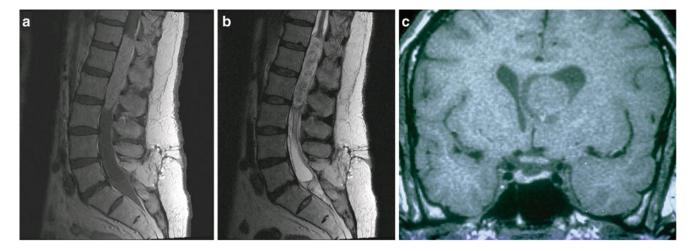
(A, B) Myxopapillary ependymoma. Sagittal T1-weighted and T2-weighted images both show a hyperintense lesion. (C) Subependymoma. These lesions tend to be nodular, circumscribed, and intraventricular; this example is isointense on coronal T1-weighted MR imaging
